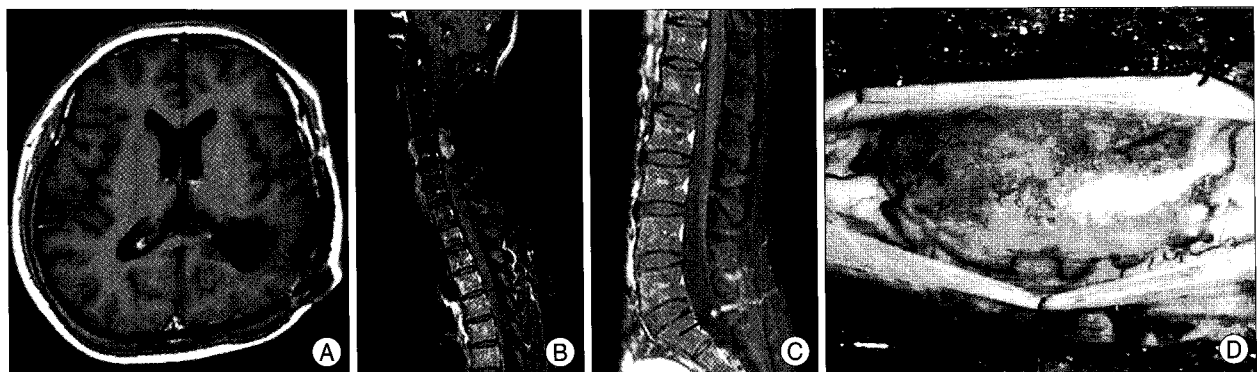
A, B, and C : Gadolinium-enhanced magnetic resonance imaging (MRI) on July 2007. Cranial MRI (A) reveals no tumor recurrence. Spinal MRI of the cervical (B) and lumbar (C) reveals an intradural extramedullary mass from the C4 to C5 vertebral levels and a small nodular tumor in cauda equina (arrow). D : An intraoperative photograph reveals the intradural extramedullary tumor located at dorsal surface of the spinal cord of the C3-C6 vertebral levels.
